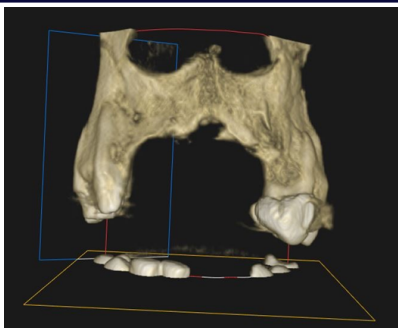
CBCT view of maxilla (single quadrant with Field of view of 5x5cm)
